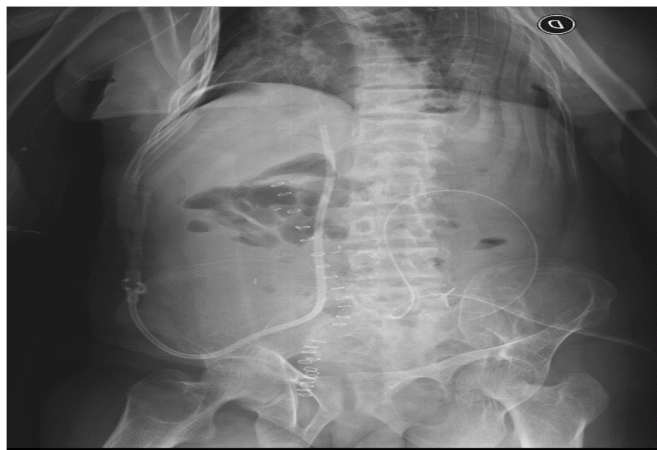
X-ray shows of IVC catheter
